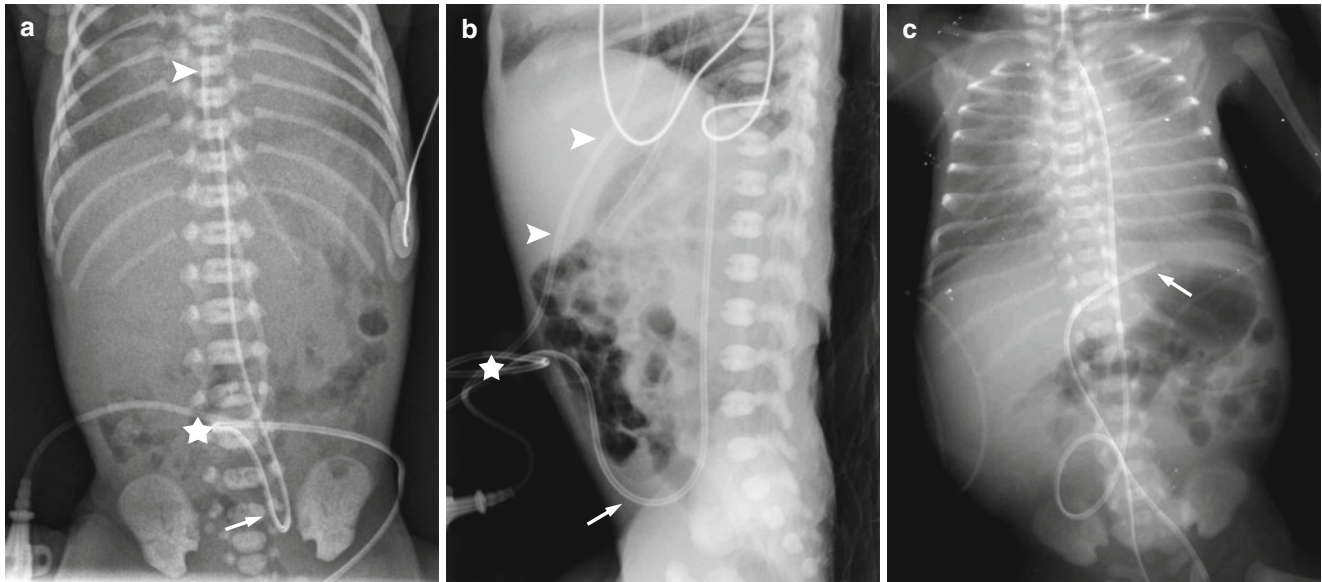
Umbilical vessel catheterization. (a, b) Frontal (a) and cross-table lateral (b) radiographs of the abdomen show an umbilical arterial catheter (*arrow*) and umbilical venous catheter (*arrowhead*) in a neonate. The arterial catheter initially proceeds caudally via the umbilical artery, then loops cephalad into the aorta with the tip at the level of T9, whereas the venous catheter proceeds cephalad as it passes via the ductus venosus into the inferior vena cava and into the right
